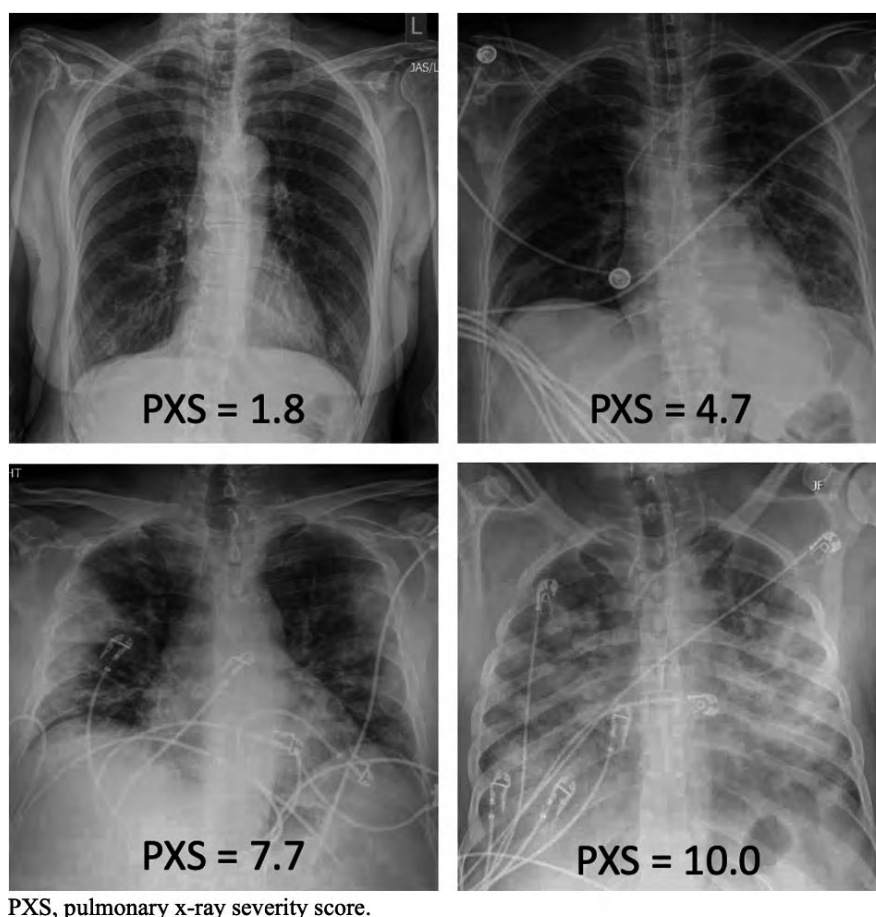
Examples of chest radiographs from patients with COVID-19 and their associated Pulmonary X-ray Severity (PXS) scores.
